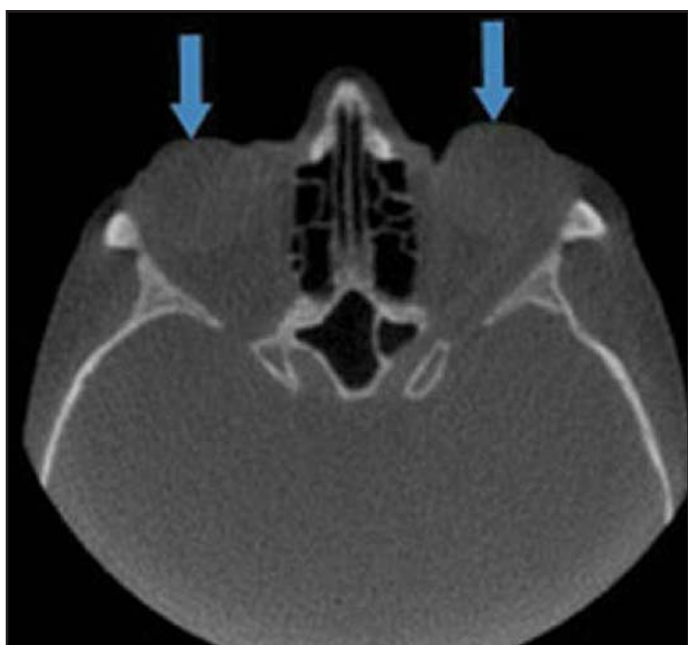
CBCT Image taken for follow-up evaluation. Image reveals proptosis of the left eye.
